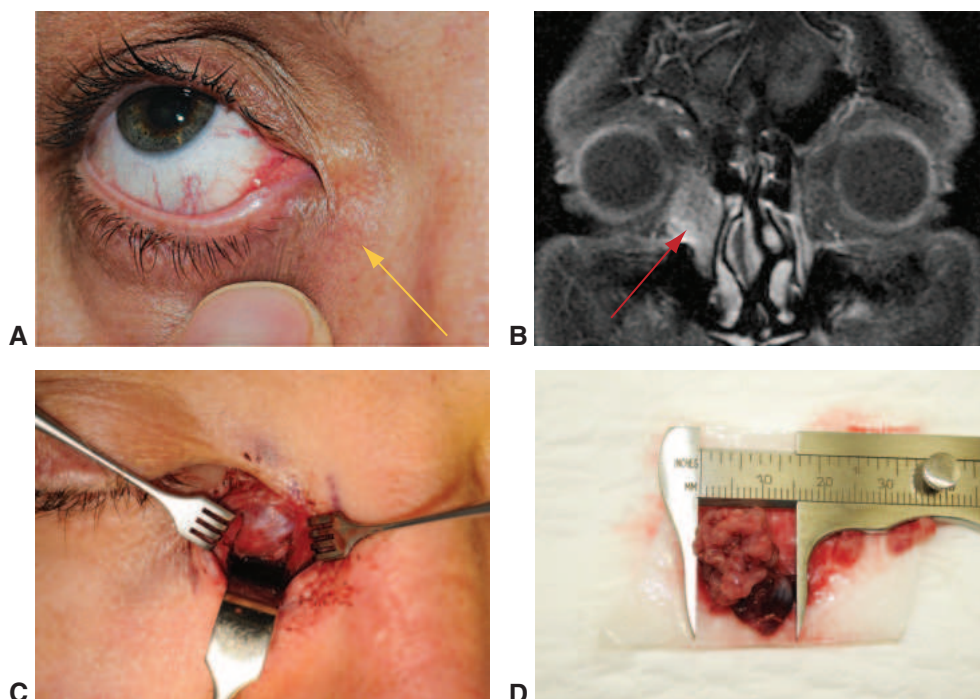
Papillary squamous cell carcinoma of the right lacrimal sac. A, Palpable mass over the right lacrimal sac (arrow). B, Magnetic resonance imaging scan shows a mass within the right lacrimal sac (arrow). C, Incisional biopsy through an external approach. D, Lacrimal sac biopsy reveals papillary squamous cell carcinoma. (Courtesy of Bobby S. Korn, MD, PhD.)
